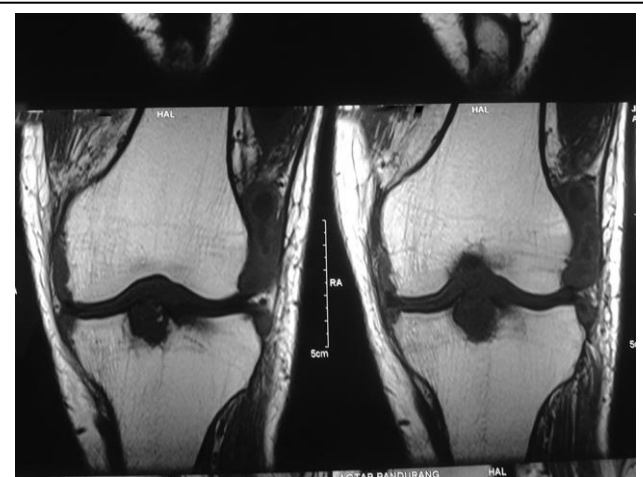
MRI of the knee joint T2 Image (a) and (b) showing periarticular intraosseous cyst.
